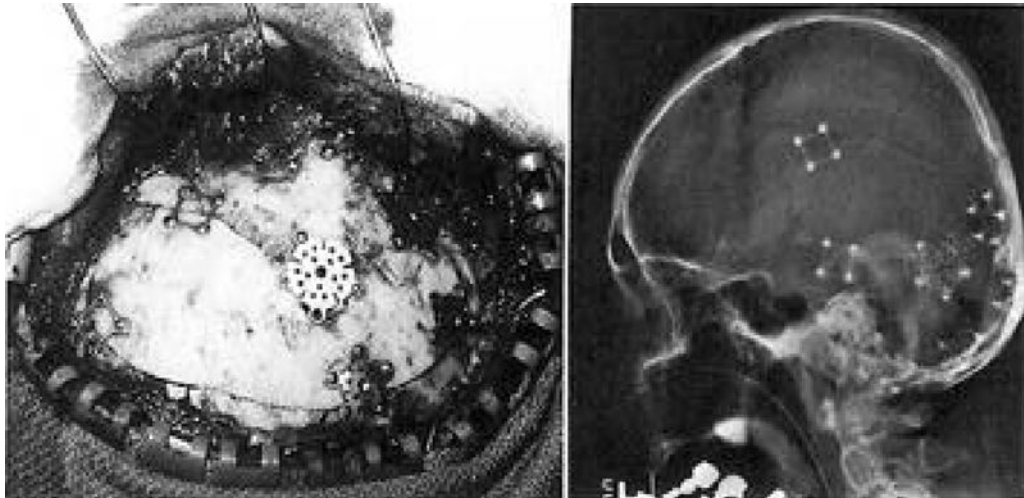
Left:* Intraoperative photograph demonstrating the use of the miniplate system for fixation of the bone flaps. Note that replacing the outer table of mastoid bone buttresses the fat graft placed in the drilled mastoid cavity below. Burr holes are covered with titanium burr-hole covers. *Right:* Postoperative skull radiograph showing the bone flaps and various miniplates used for fixation.
